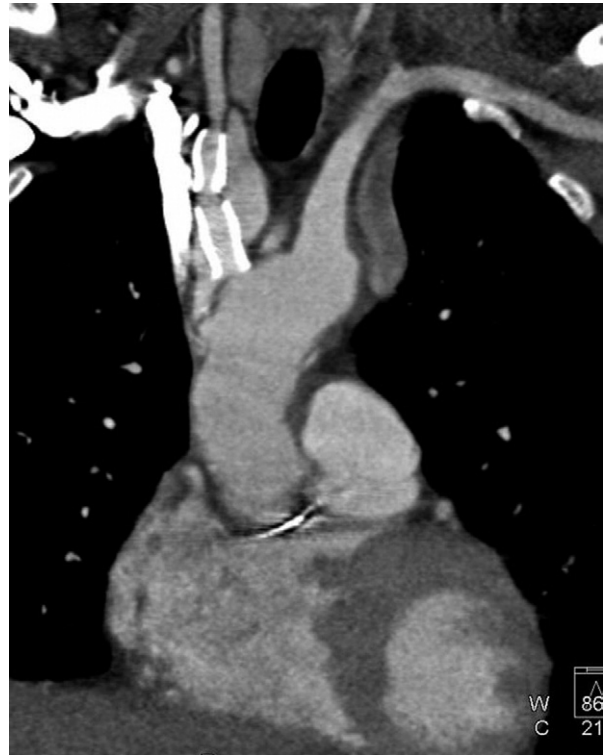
Computed tomographic angiogram 2.5 years after treatment showing patent stents in the innominate and right common carotid arteries.
